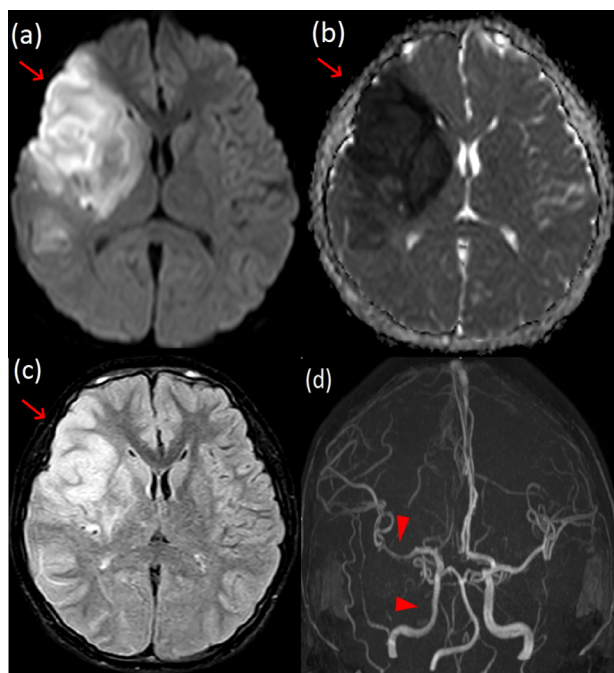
MRI performed on day 2 of presentation with diffusion-weighted imaging (A), apparent diffusion coefficient map (B) and FLAIR images (C) demonstrating restricted diffusion and cytotoxic edema (red arrows) in the right frontal and parietal lobes consistent with an acute infarct in the right MCA territory. The TOF-MRA images (D) demonstrating reduced caliber of the right ICA and MCA (red arrowheads).
